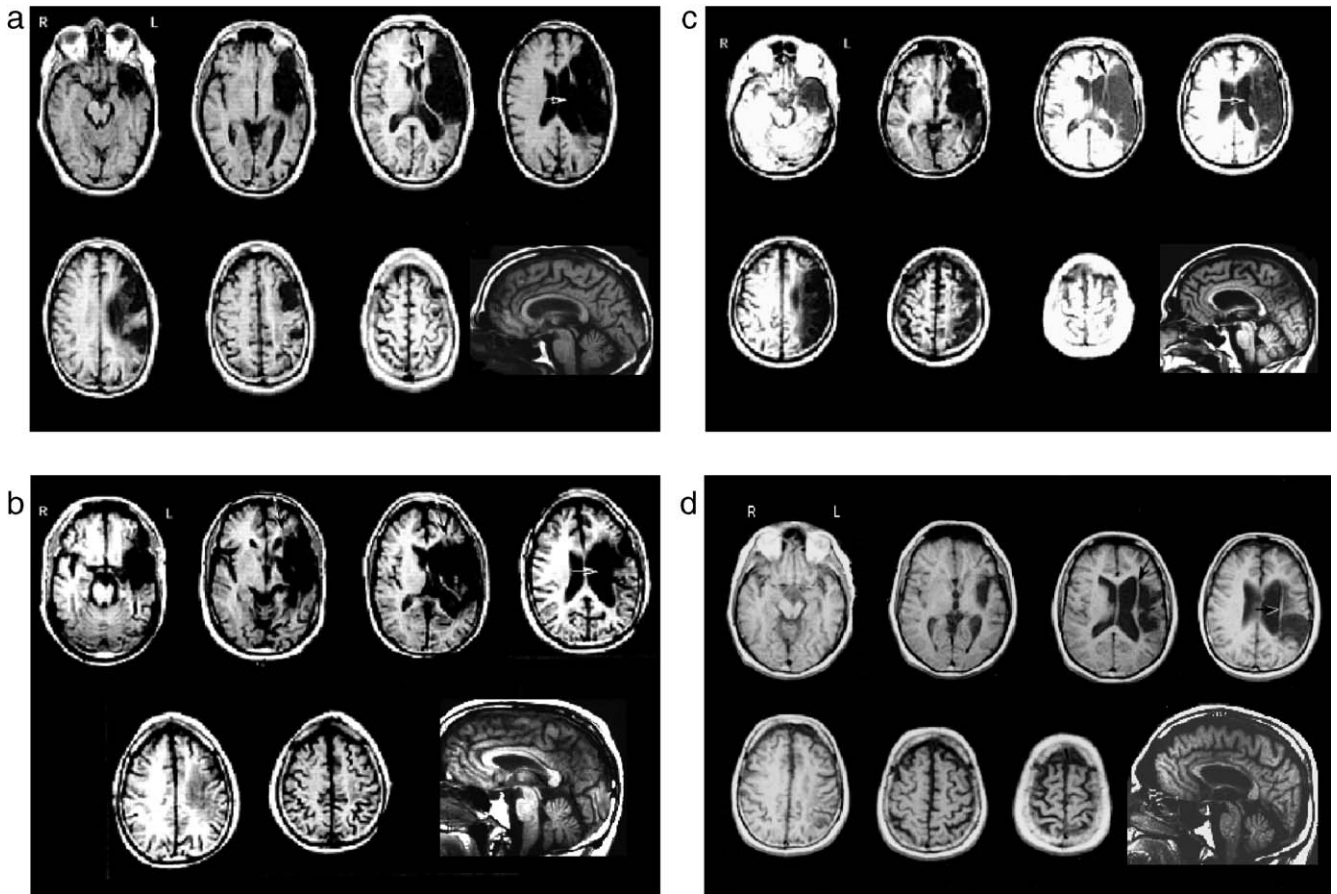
Anatomical T1-weighted MRI scans showing left hemisphere lesions for the four nonfluent aphasia patients (a–d). Included within each lesion site description is information on the two white matter areas near ventricle relevant to presence and severity of nonfluent speech: (1) medial subcallosal fasciculus area, adjacent to left frontal horn; and (2) middle 1/3 periventricular white matter area, adjacent to body of left lateral ventricle. (See also Fig. 2) For each patient, a mid-sagittal slice showing atrophy in the corpus callosum is also included. (a) Nonfluent aphasia patient 1 (53 years old, M, 4 years poststroke). Lesion was present in only one of the two white matter areas near ventricle: (1) medial subcallosal fasciculus area was largely spared (black arrow near frontal horn); (2) middle 1/3 periventricular white matter area had extensive lesion (horizontal white and black arrow). Lesion was also present in Broca's area; frontal operculum; sensorimotor mouth region; anterior and posterior supramarginal gyrus; angular gyrus; and portions of Wernicke's area and posterior middle temporal gyrus (BA 37). (b) Nonfluent aphasia patient 2 (47 years old M, 5 years poststroke). Extensive lesion was present in both of the white matter areas near ventricle: (1) medial subcallosal fasciculus area (black arrows near frontal horn); (2) middle 1/3 periventricular white matter area (horizontal white and black arrow). Lesion was also present in Broca's area; frontal operculum; sensorimotor mouth region; portions of anterior and posterior supramarginal gyrus; and angular gyrus (some lesion was patchy and deep to these areas). Extensive lesion was present in Wernicke's area, and partial lesion, in the posterior middle temporal gyrus (BA 37). (c) Nonfluent aphasia patient 3 (60 years old, M, 9 years poststroke). Extensive lesion was present in both of the white matter areas near ventricle: (1) medial subcallosal fasciculus area (black arrow near frontal horn on lower slice, and black arrow near frontal horn on next slice); (2) middle 1/3 periventricular white matter area (horizontal white and black arrow). Lesion was also present in Broca's area; frontal operculum; sensorimotor mouth region; anterior and posterior supramarginal gyrus; angular gyrus; Wernicke's area; most of the posterior middle temporal gyrus (BA 37); anterior temporal lobe; high parietal and frontal lobe. (d) Nonfluent aphasia patient 4 (63 years old M, 5 years poststroke). Extensive lesion was present in both of the white matter areas near ventricle: (1) medial subcallosal fasciculus area (black arrow near frontal horn); (2) middle 1/3 periventricular white matter area (horizontal white and black arrow at body of lateral ventricle slice). This was primarily a subcortical lesion centered over the putamen with the white matter lesion extension into (1) and (2), compatible with severe nonfluent speech. There was no lesion in Broca's or Wernicke's cortical areas. Some cortical lesion was present in the supramarginal and angular gyrus areas.
